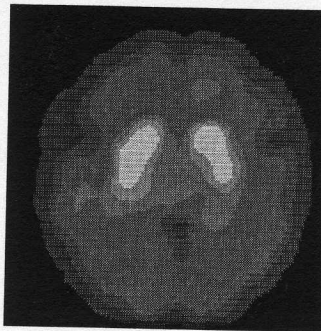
CA segmented neuroreceptor SPECT image (after anisotropic diffusion)
